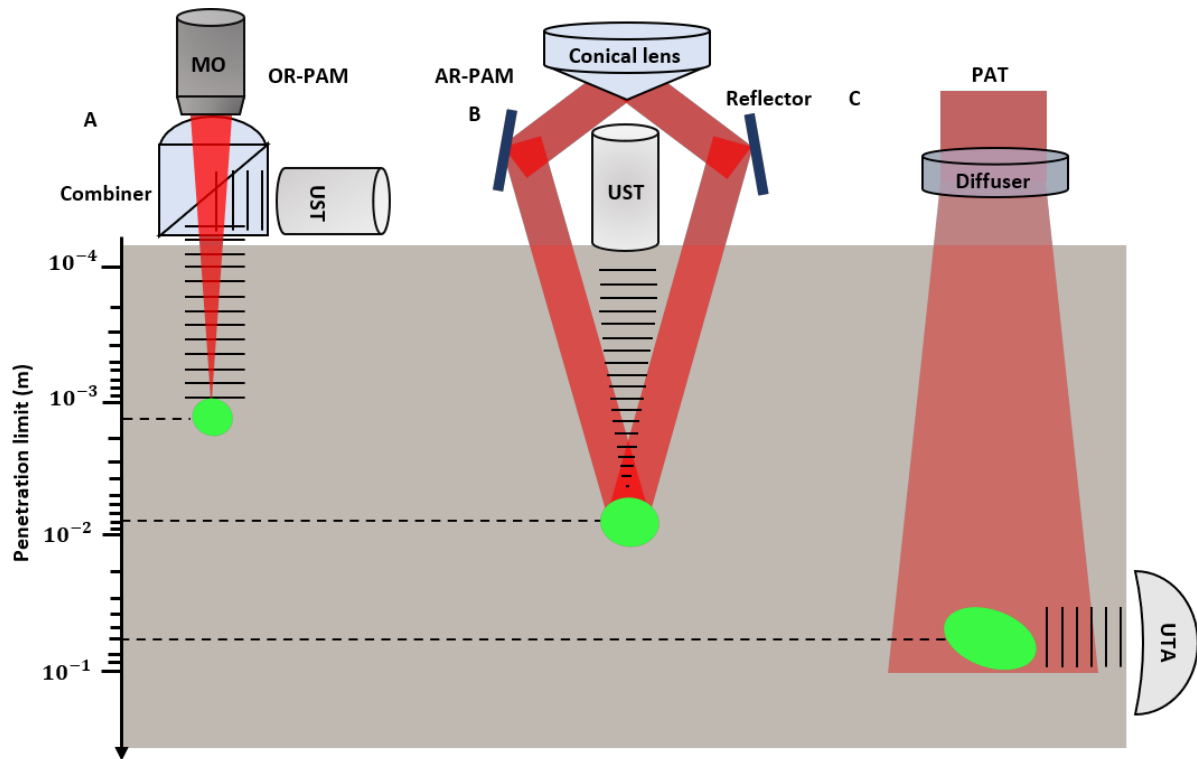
Signal generation and detection in different implementations of PAI and penetration limits in scattering tissue. (A) Reflection-mode OR-PAM system with an optical–acoustic combiner that transmits light but reflects sound. (B) AR-PAM system where the laser light is poorly focused. (C) PAT system with ultrasonic transducer array (UTA). The laser beam is expanded and homogenized by a diffuser to provide widefield illumination.
